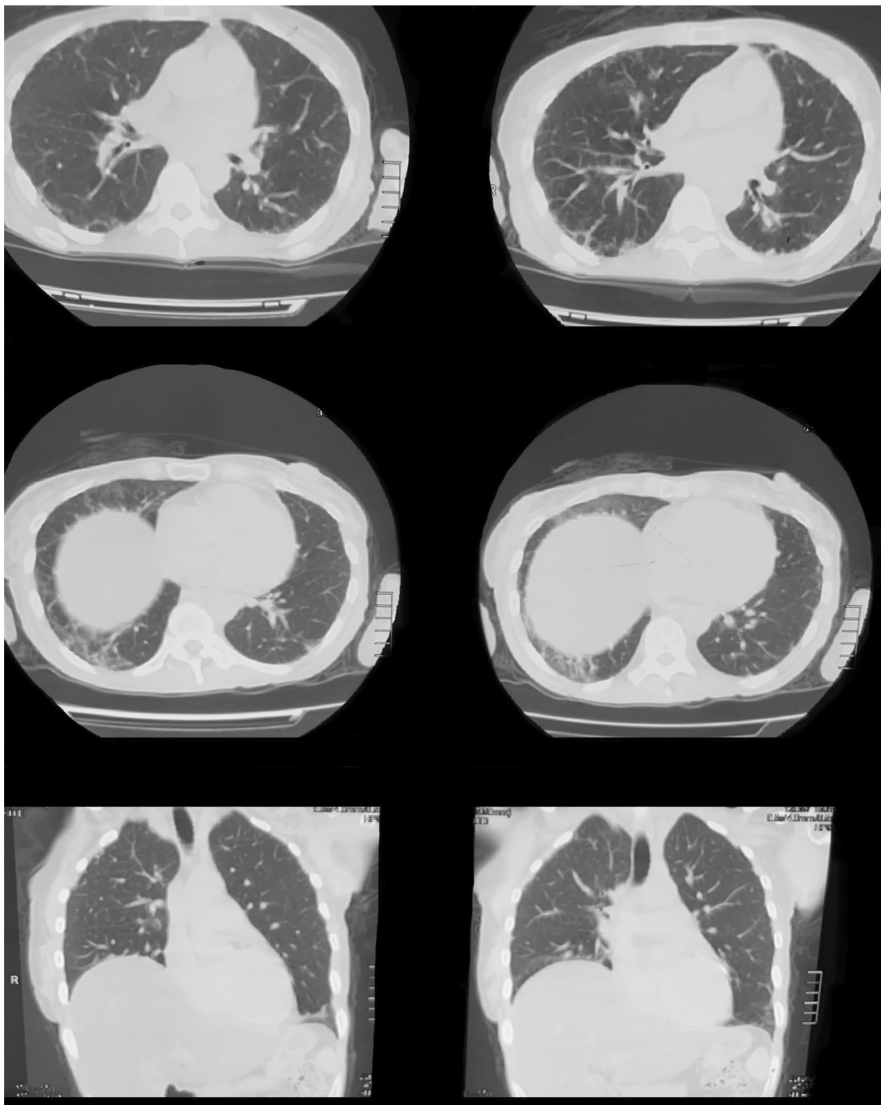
A computed tomography (CT) of the chest showed that both lungs had interstitial changes, ground glass opacification with the lower lobes being the most affected, and a small amount of pleural thickening on both sides.
